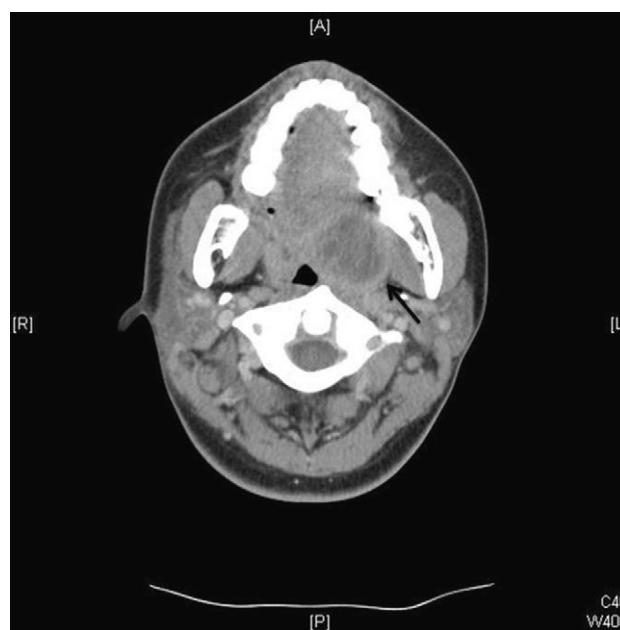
Example of a peritonsillar abscess demonstrated on contrast-enhanced axial computed tomography. Arrow shows a 3 × 3 cm abscess formation with ring of enhancement.
